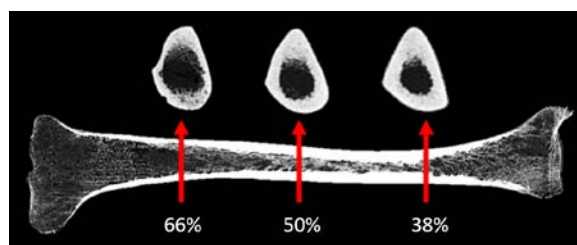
Representative whole-bone CT scan with VOIs defined at 38%, 50% and 66% of total length.
